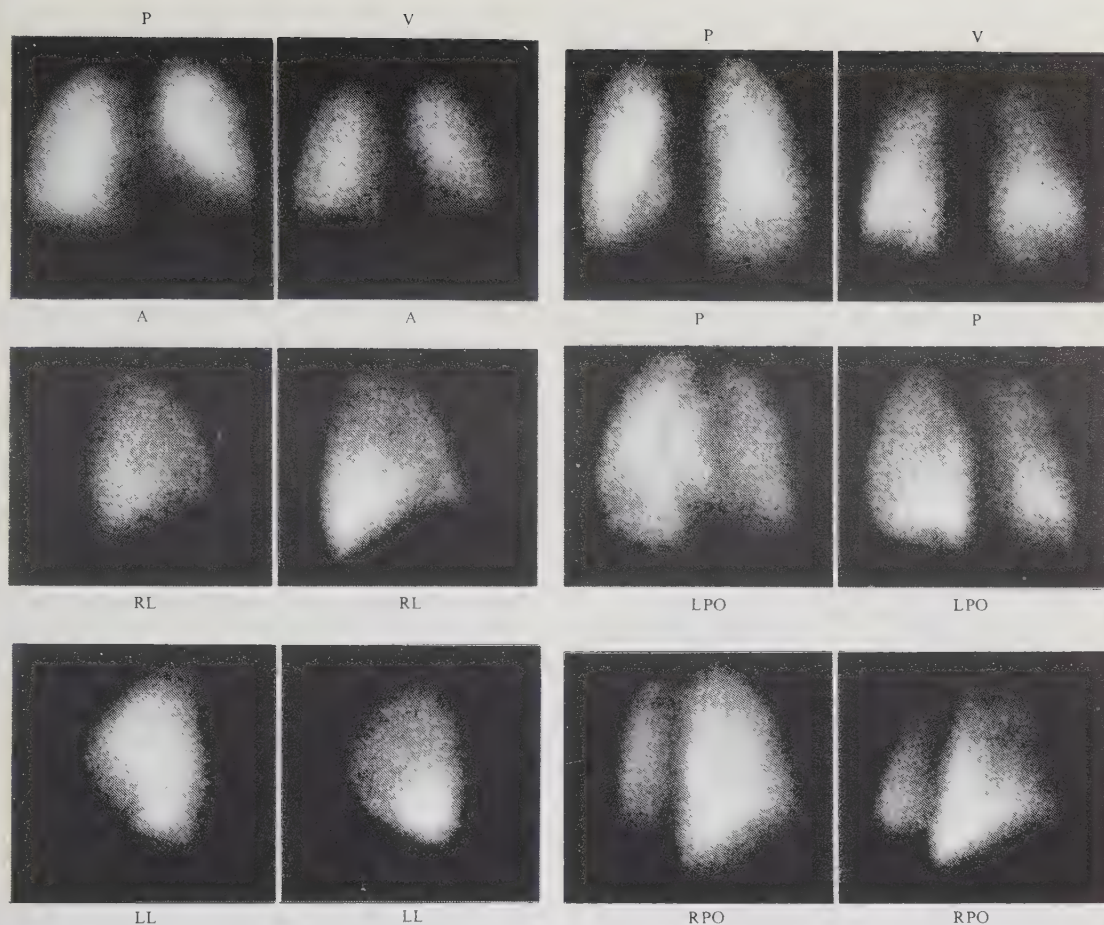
Perfusion (*P*) and ventilation (*V*) scintigraphy. Projections: Anterior (*A*), posterior (*P*), right lateral (*RL*), left lateral (*LL*), right posterior oblique (*RPO*), left posterior oblique (*LPO*). Triangular defect (h_2) in the left posterior oblique projection without a corresponding defect in the ventilation scintigraphy
